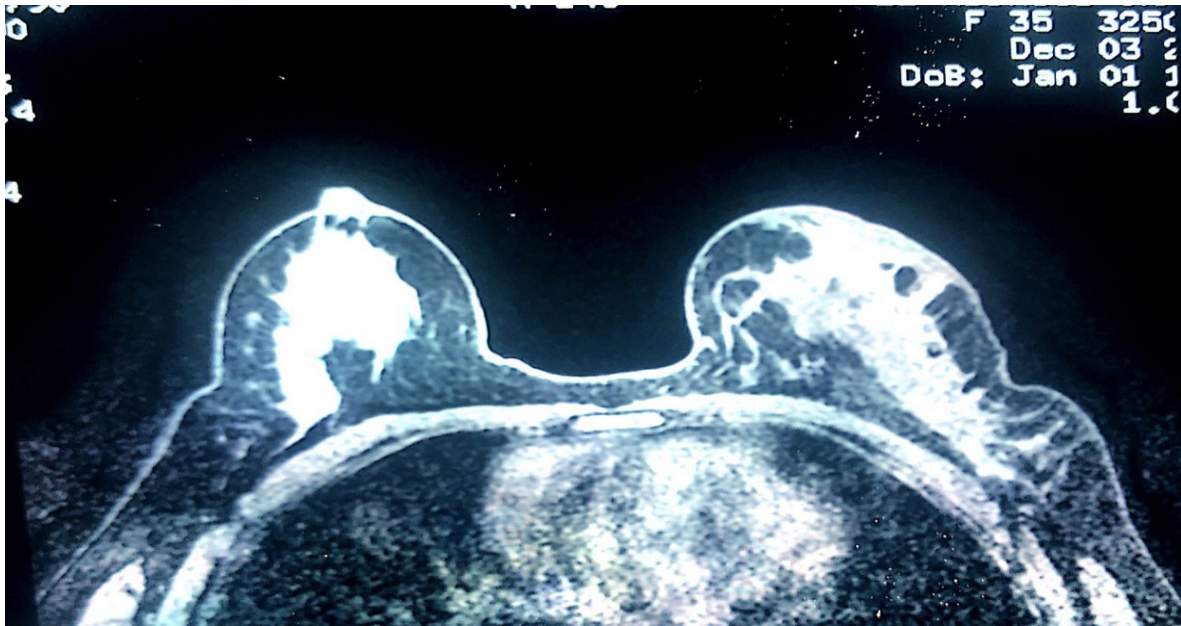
MRI aspect of left mass enhancement at the upper-external quadrant.
